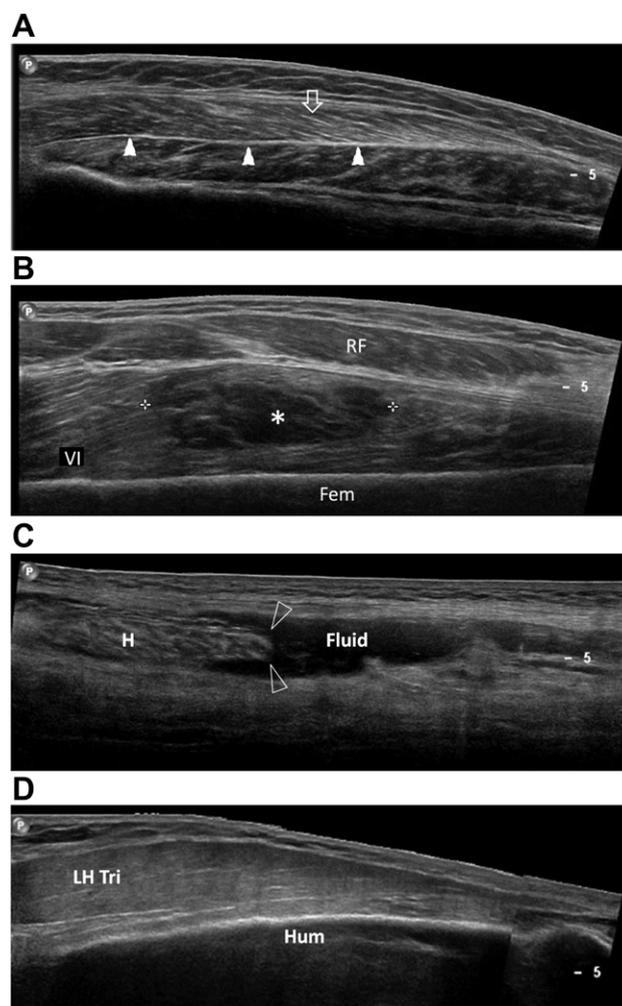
Ultrasound pictures from various pathologies of the muscles. (A) Normal sonographic picture of the muscle. The perimysiums depict parallel echogenic lines (open arrow) and the fascial (arrowheads) between the muscles. (B) Partial tear of the muscle showing hypoechoic area (*) in the vastus intermedius muscle (VI) between rectus femoris muscle (RF) and femoral bone. (C) Complete rupture of right hamstring muscle (H). Margin of ruptured muscle (open arrowheads) can be seen in the anechoic fluid. (D) Rhabdomyolysis of long head of triceps muscles (LH Tri) showing diffused echogenic change of the muscle. The perimysiums in the muscle are hard to identify.
